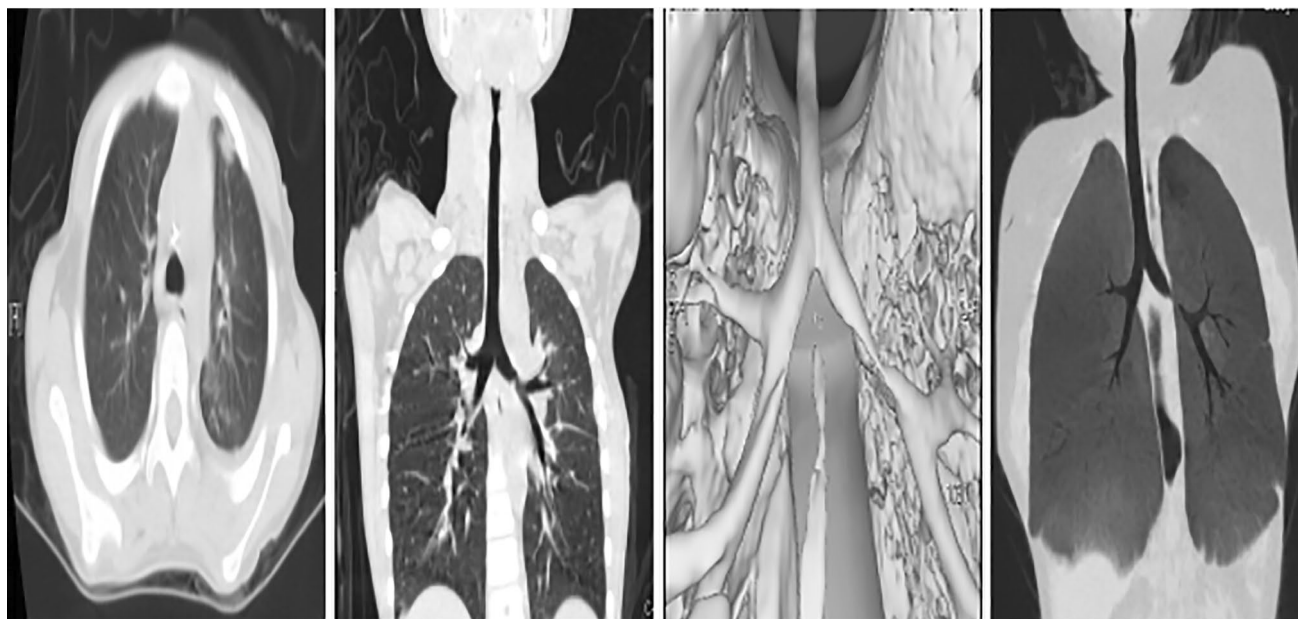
Postoperative CT images
